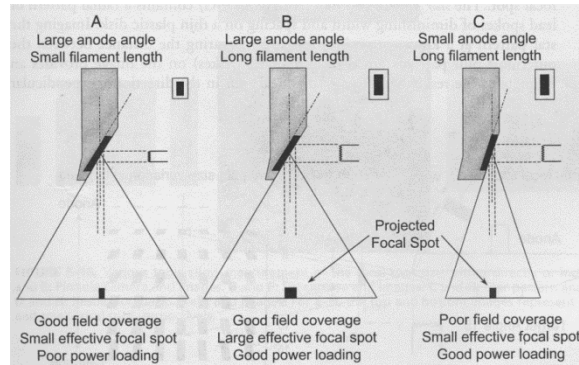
The effects of different focal spot size (filament size in traditional x-ray sources) and anode angle. [4]
